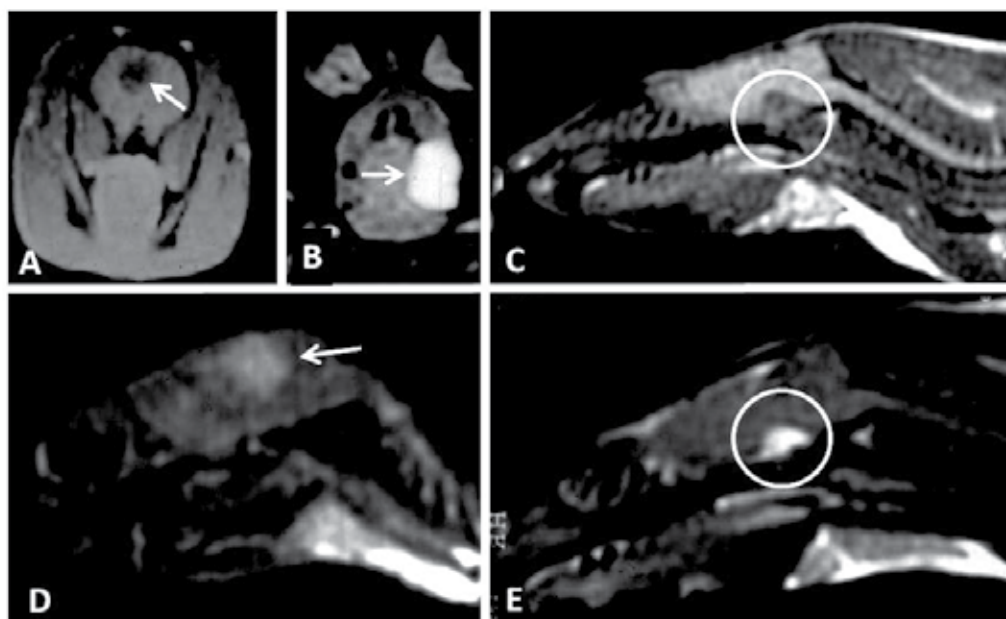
Magnetic Resonance Images showing ENU-induced brain tumors. A, B and D were intraparenchymatous oligodendroglial-like tumors. C and E were extraparenchymatous tumors with features of malignant schwannomas.
